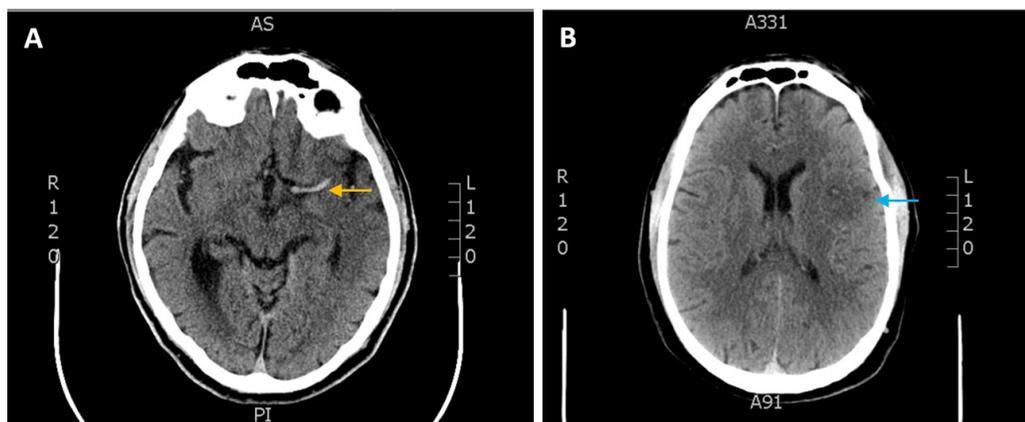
Non-contrast CT signs in acute ischemic stroke. A: Dense Middle Cerebral Artery sign (left), shown by yellow arrow. B: Sulcal effacement in territory of left Middle Cerebral Artery, shown by blue arrow.
